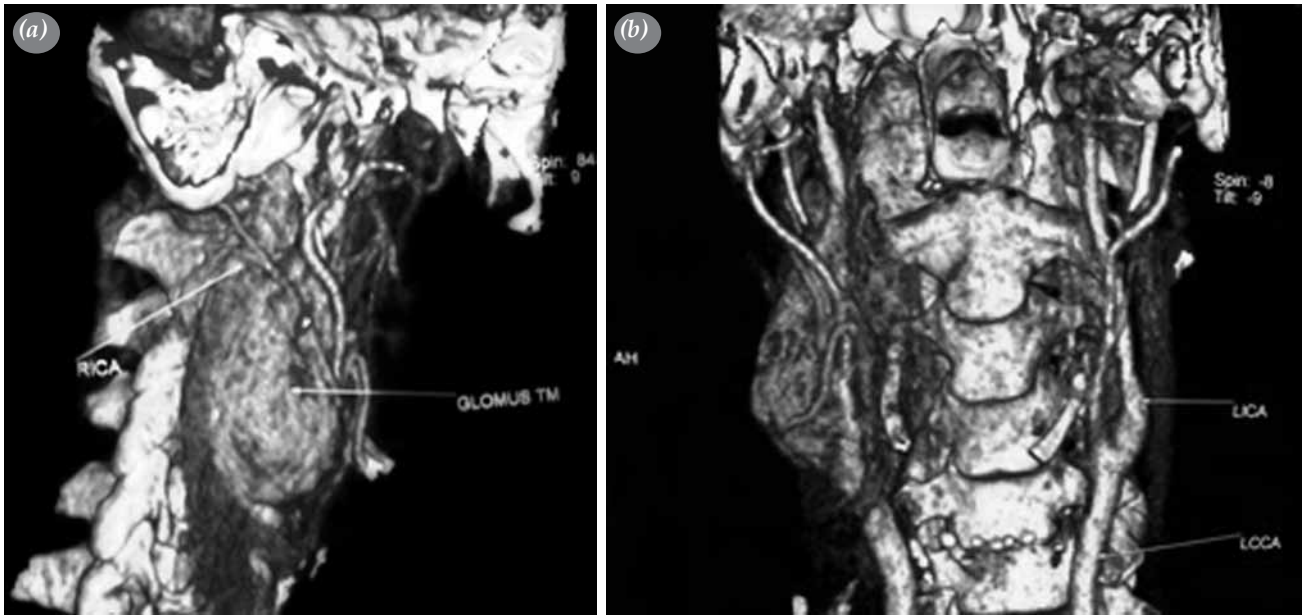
(a, b) Preoperative computed tomography angiography of a right carotid body tumor.
